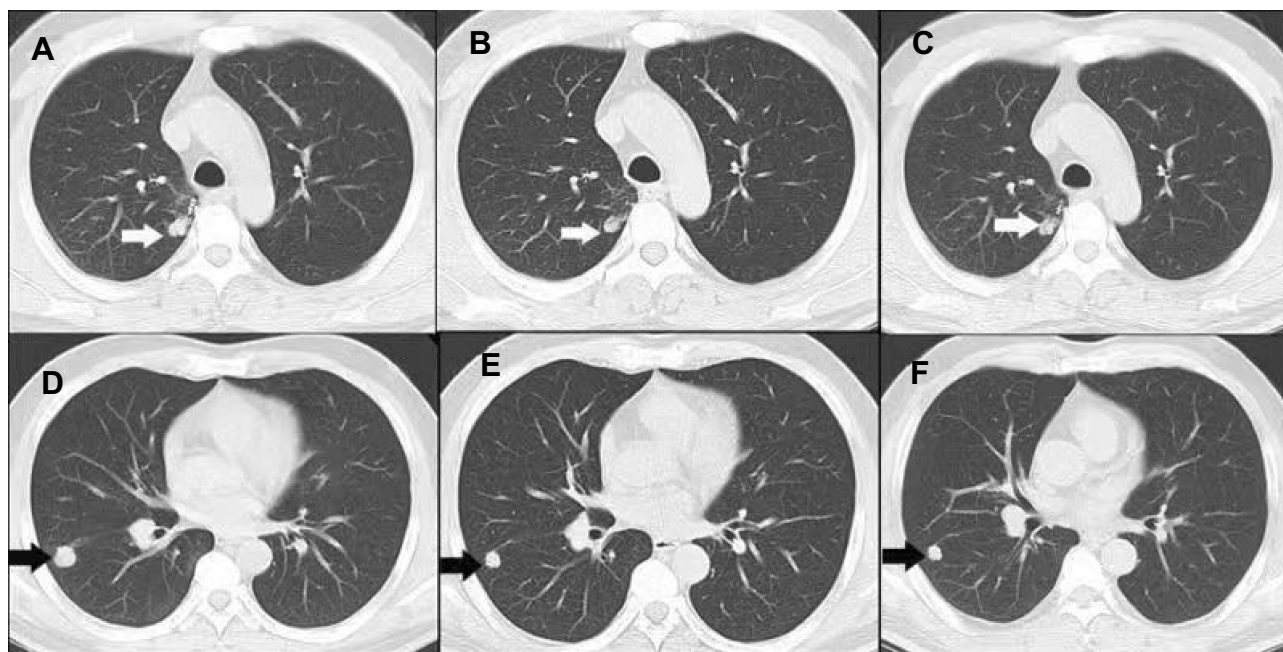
Chest CT scans before and after anlotinib treatment. (A and D): Before anlotinib treatment, two measurable tumor lesions were shown. (B and E) After two cycles of anlotinib treatment, a Partial response was observed. (C and F) After six cycles of anlotinib treatment, a continued partial response was observed. The white and black arrowheads aim at two measurable tumor lesions, respectively. Response assessment was based on RECIST guideline version 1.1.
